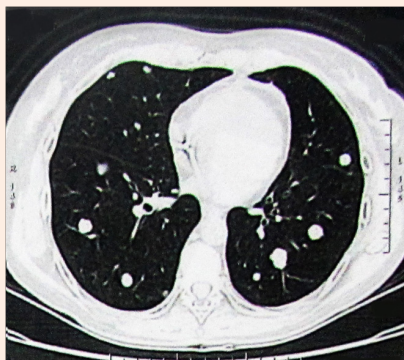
Chest CT scan showing multiple bilateral pulmonary nodules of up to 15mm.
